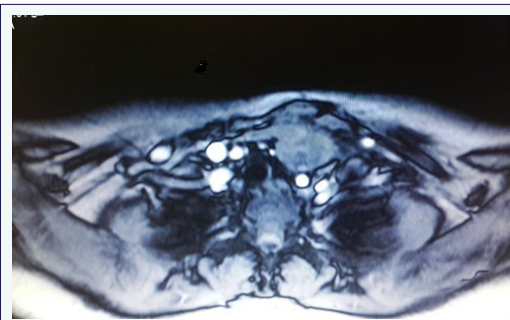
Magnetic Resonance Imaging (MRI) 2D Time of Flight (TOF) of the neck shows loss of flow related enhancement of left IJV with a filling defect in the left IJV leaving a 4 mm diameter as a remaining lumen, the filling defect was adjacent to the enlarged LN which appeared to have a tunnel towards the overlying skin.
